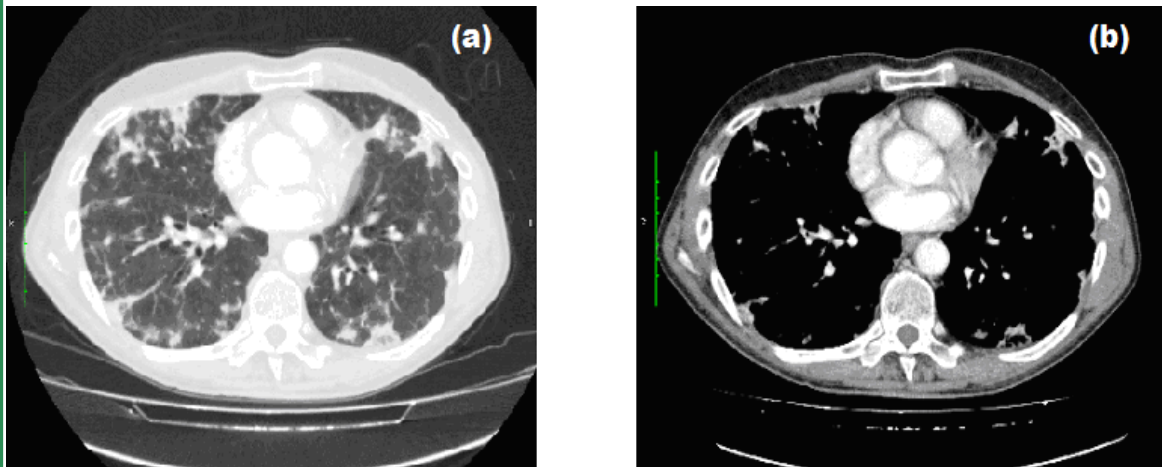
(a) CT scan shows patchy areas of consolidation and ground glass opacities with subpleural and bilateral distribution in the lower lobes. High-resolution CT images performed after three (b) and six (c) months of corticosteroid treatment show the resolution of the consolidations.
